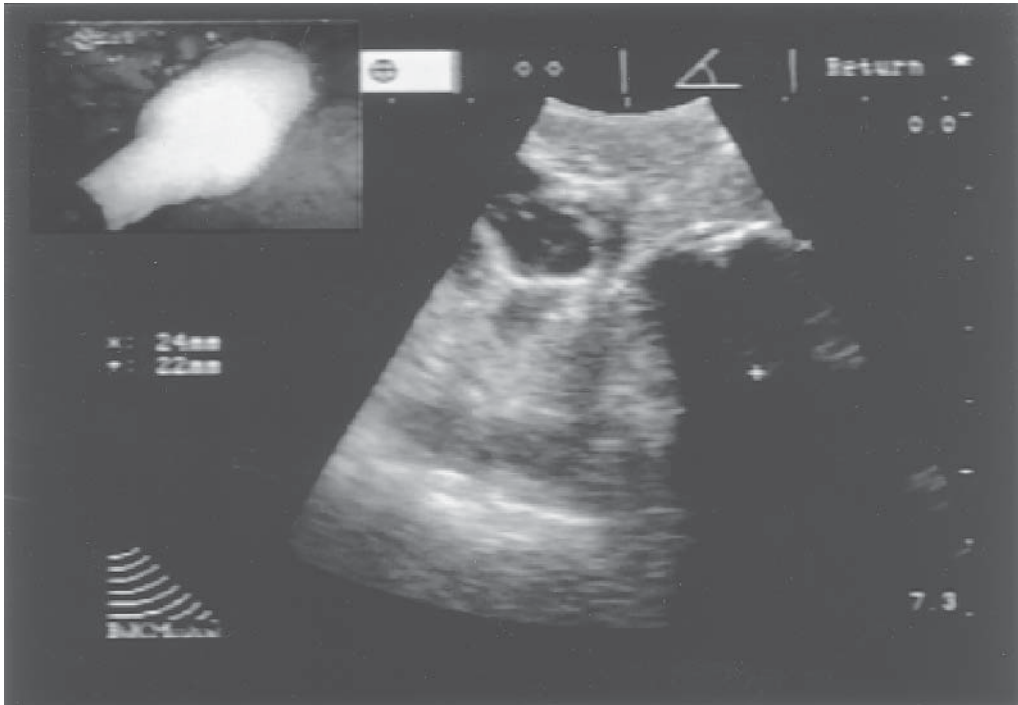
Ultrasound image of the ice-ball. The semicircular hyperechoic image represents the advancing edge of the ice-ball. The body of the ice-ball is anechoic. Picture-in-picture inset shows a laparoscopic view of the ice-ball.
